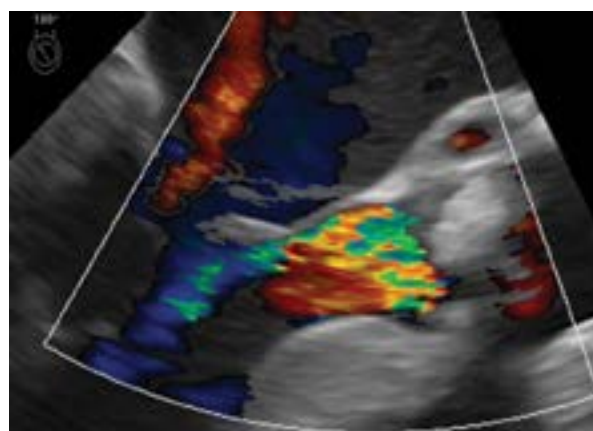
Mid-oesophageal long axis transoesophageal echocardiographic view at 130° showing aortic regurgitation
